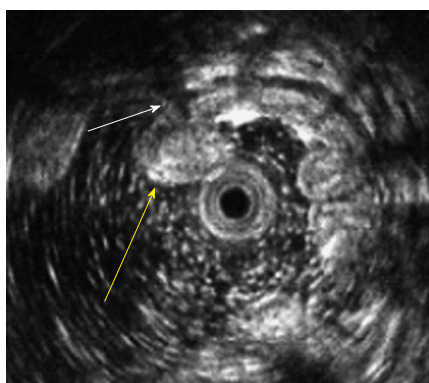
Endoscopic ultrasonography revealed a homogeneously hyperechoic submucosal mass (yellow arrow) with clear margin and a hypoechoic tunnel inside (white arrow).
